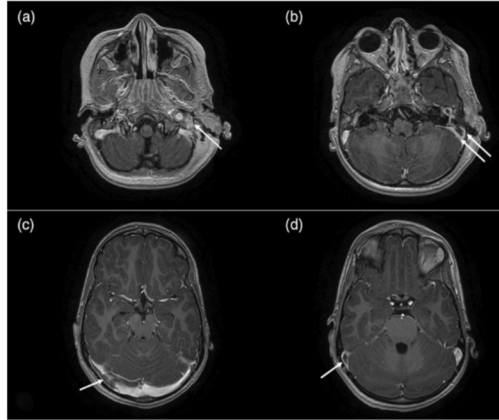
Magnetic resonance imaging (MRI) scan of a 3-year-old male with left mastoiditis (a; arrow) and cerebral sinovenous thrombosis (CSVT) in the left sigmoid sinus (b; double arrow), gadolinium enhanced T1 axial sequence. MRI of a 11-year-old male with Behcet disease and extensive CSVT in the right transverse (c) and sigmoid sinuses (d; arrows), gadolinium enhanced T1 axial sequence
